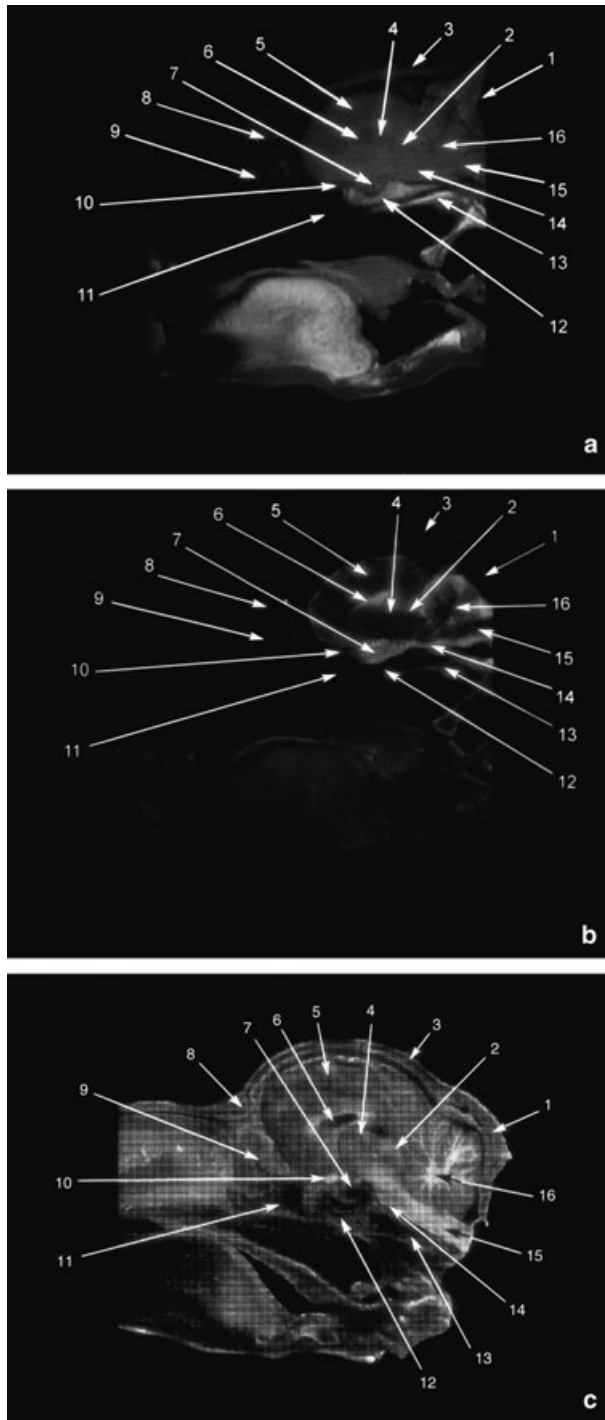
(a) T1-weighted mid-sagittal MR image; (b) T2-weighted mid-sagittal MR image, and (c) gross section of the camel head. 1, Occipital squama; 2, mesencephalic tectum; 3, parietal bone; 4, thalamus; 5, cerebral hemisphere: cerebral cortex; 6, fourth ventricle; 7, pituitary gland; 8, frontal bone and frontal sinus; 9, ethmoid labyrinth; 10, optic chiasm; 11, body of presphenoid bone; 12, body of basisphenoid bone; 13, basilar part of occipital bone; 14, myelencephalon; 15, pons; 16, cerebellar vermis.
